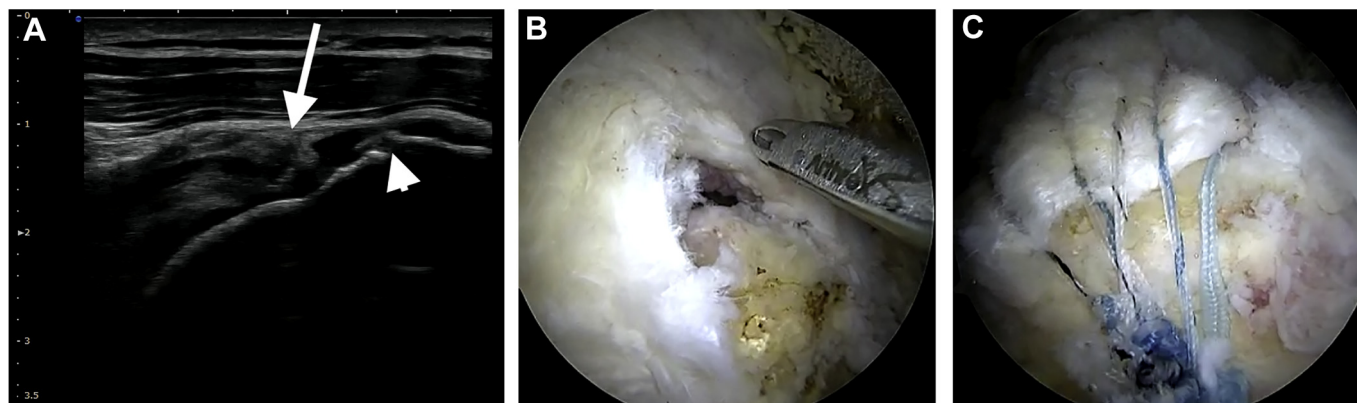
(A) The coronal long-axis ultrasound image demonstrating torn supraspinatus tendon stump (arrow) retracted from greater tuberosity insertion (arrowhead). (B) The intraoperative arthroscopic image from a posterolateral viewing portal demonstrating a full-thickness tear of the supraspinatus. (C) The intraoperative arthroscopic image from a lateral viewing portal demonstrating repair of the rotator cuff tear with a lateral suture anchor.
